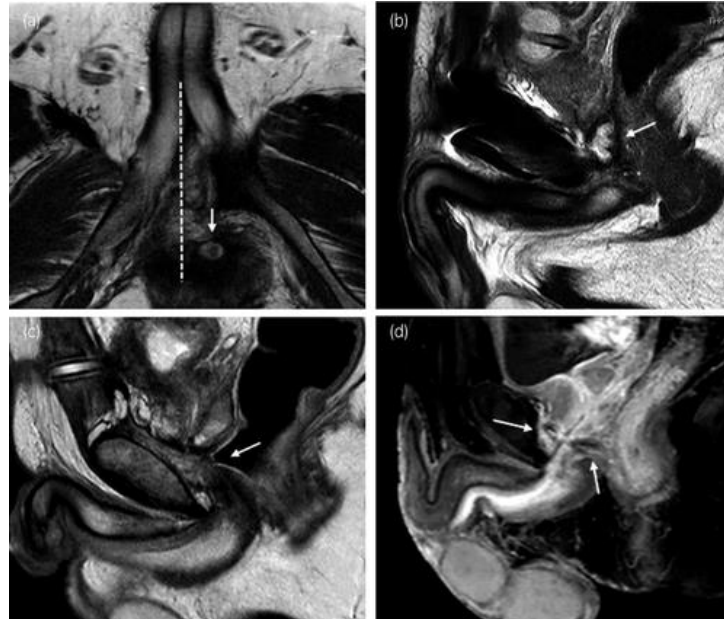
Representative preoperative MRI findings in patients with urethral stenosis after PFUI. (a) Lateral displacement of the proximal urethral end (arrow) from the midline (dotted line) in the axial T2-weighted image, (b) cavity formation just behind the proximal urethral end (arrow) in the sagittal T2-weighted image, (c) bulging of the rectum into the urethral gap (arrow) in the sagittal T2-weighted image. (d) Periurethral fistulas (arrow) in contrast-enhanced T1-weighted image.
